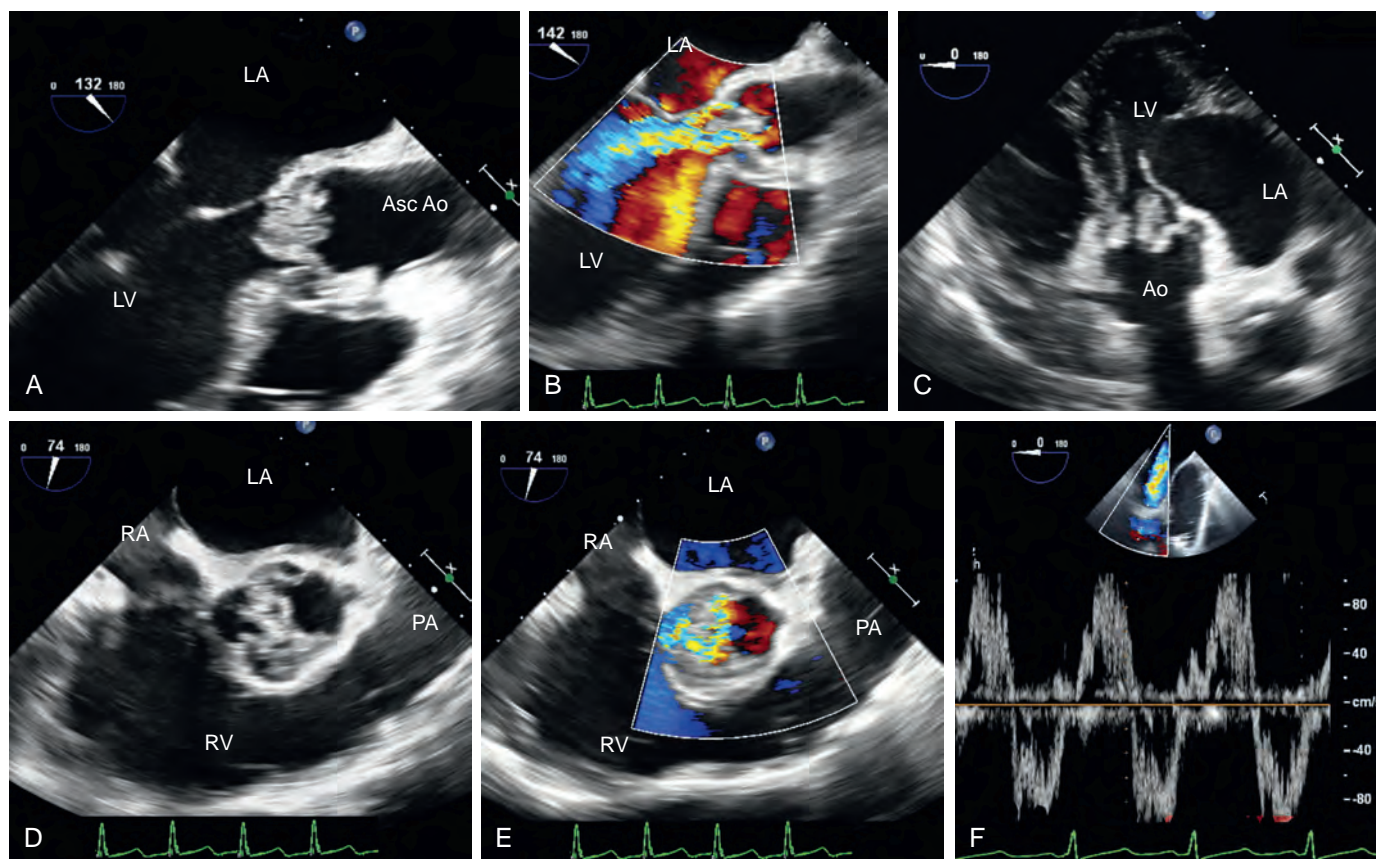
Aortic insufficiency caused by endocarditis. Endocarditis of the aortic valve (AV) can manifest with a range of leaflet/annular/aortic disease and insufficiency. (A) and (B) Significant leaflet involvement and severe insufficiency. (C) Transgastric imaging showing significant involvement of the AV. (A–C) show thickened, irregular, and flail AV leaflets, which are associated with large mobile masses. (D) and (E) AV in short-axis view with and without color Doppler, showing severe insufficiency. (F) Pulsed-wave Doppler of the ascending aorta showing diastolic flow reversal consistent with severe dysfunction. Asc Ao, Ascending aorta; LA, left atrium; LV, left ventricle; PA, Pulmonary artery; RA, right atrium; RV, right ventricle.
